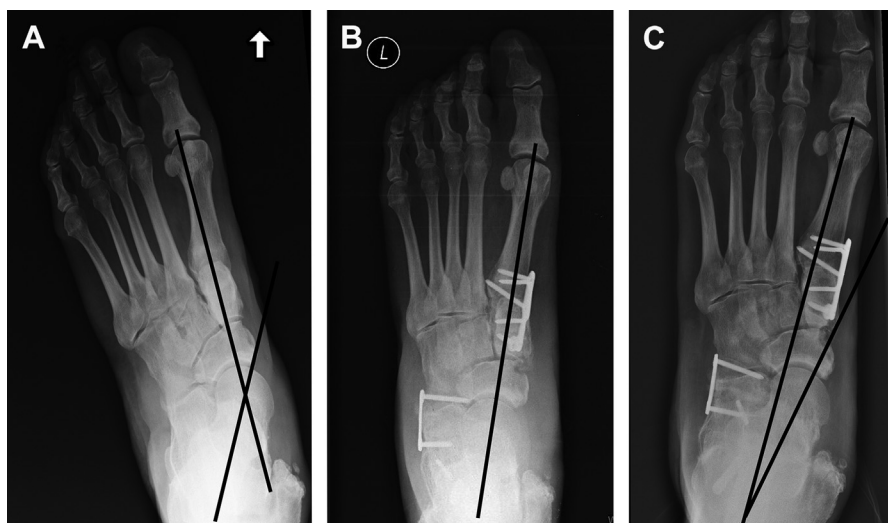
Preoperative AP radiograph (A) with greater than 50% abduction of the TN joint. Excellent coronal plane correction (B) was thought to be achieved at 3 months following an MDCO, lateral collateral ligament (LCL), first TMT arthrodesis, spring ligament reconstruction, and FDL tendon transfer. However, at 1 year (C), despite bony union, loss of correction occurred, which was thought to be secondary to a failure to address the NC instability (Fig. 4).
